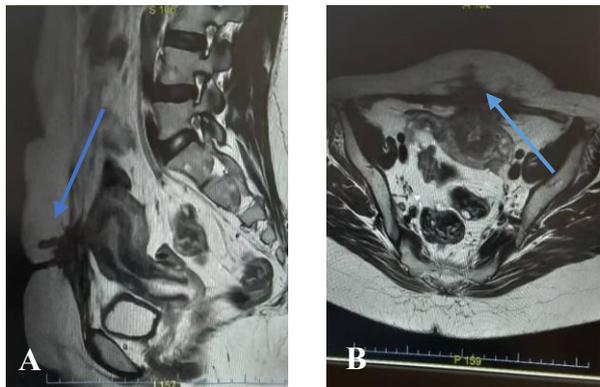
Magnetic resonance imaging, (A) the sagittal and (B) axial views that the blue arrow shows a fistula that communicates between the anterior abdominal wall and the uterine cavity
